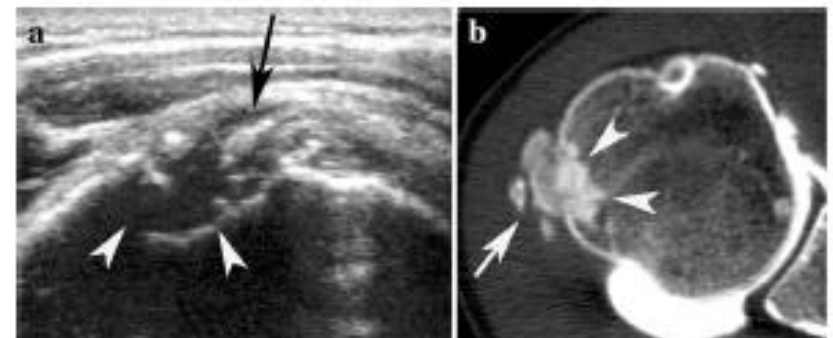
Similar lesion demonstrated by ultrasound and CT (courtesy of G. Morvan). a Ultrasound shows a heterogeneous echogenic focus in the tendon (*arrow*) that extends into a large lesion of the superior facet of the greater tuberosity of the humerus (*arrowheads*). b A CT scan confirms that the large tendinous calcification (*arrow*) extended into the subcortical bone (*arrowheads*)
